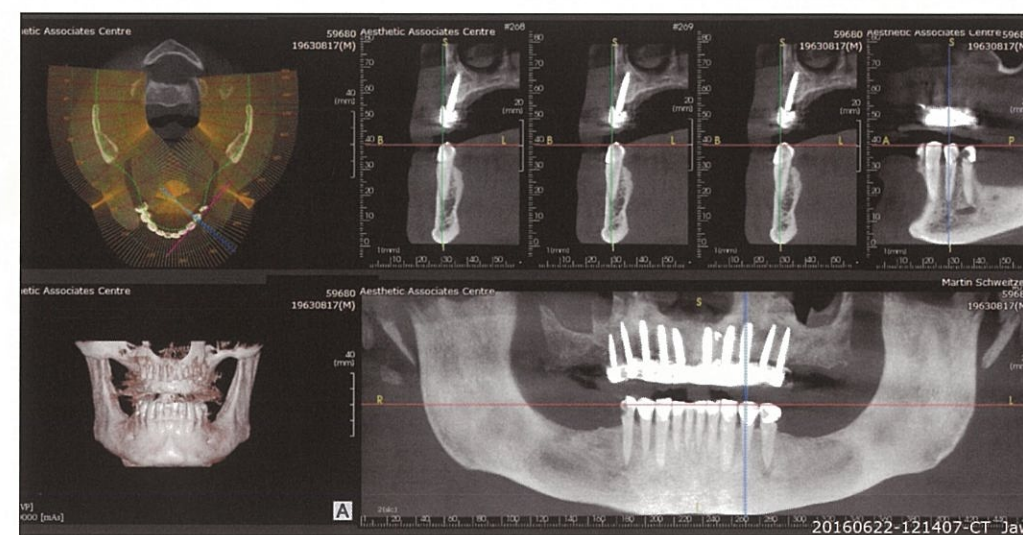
Final CBCT and panoramic radiograph.
